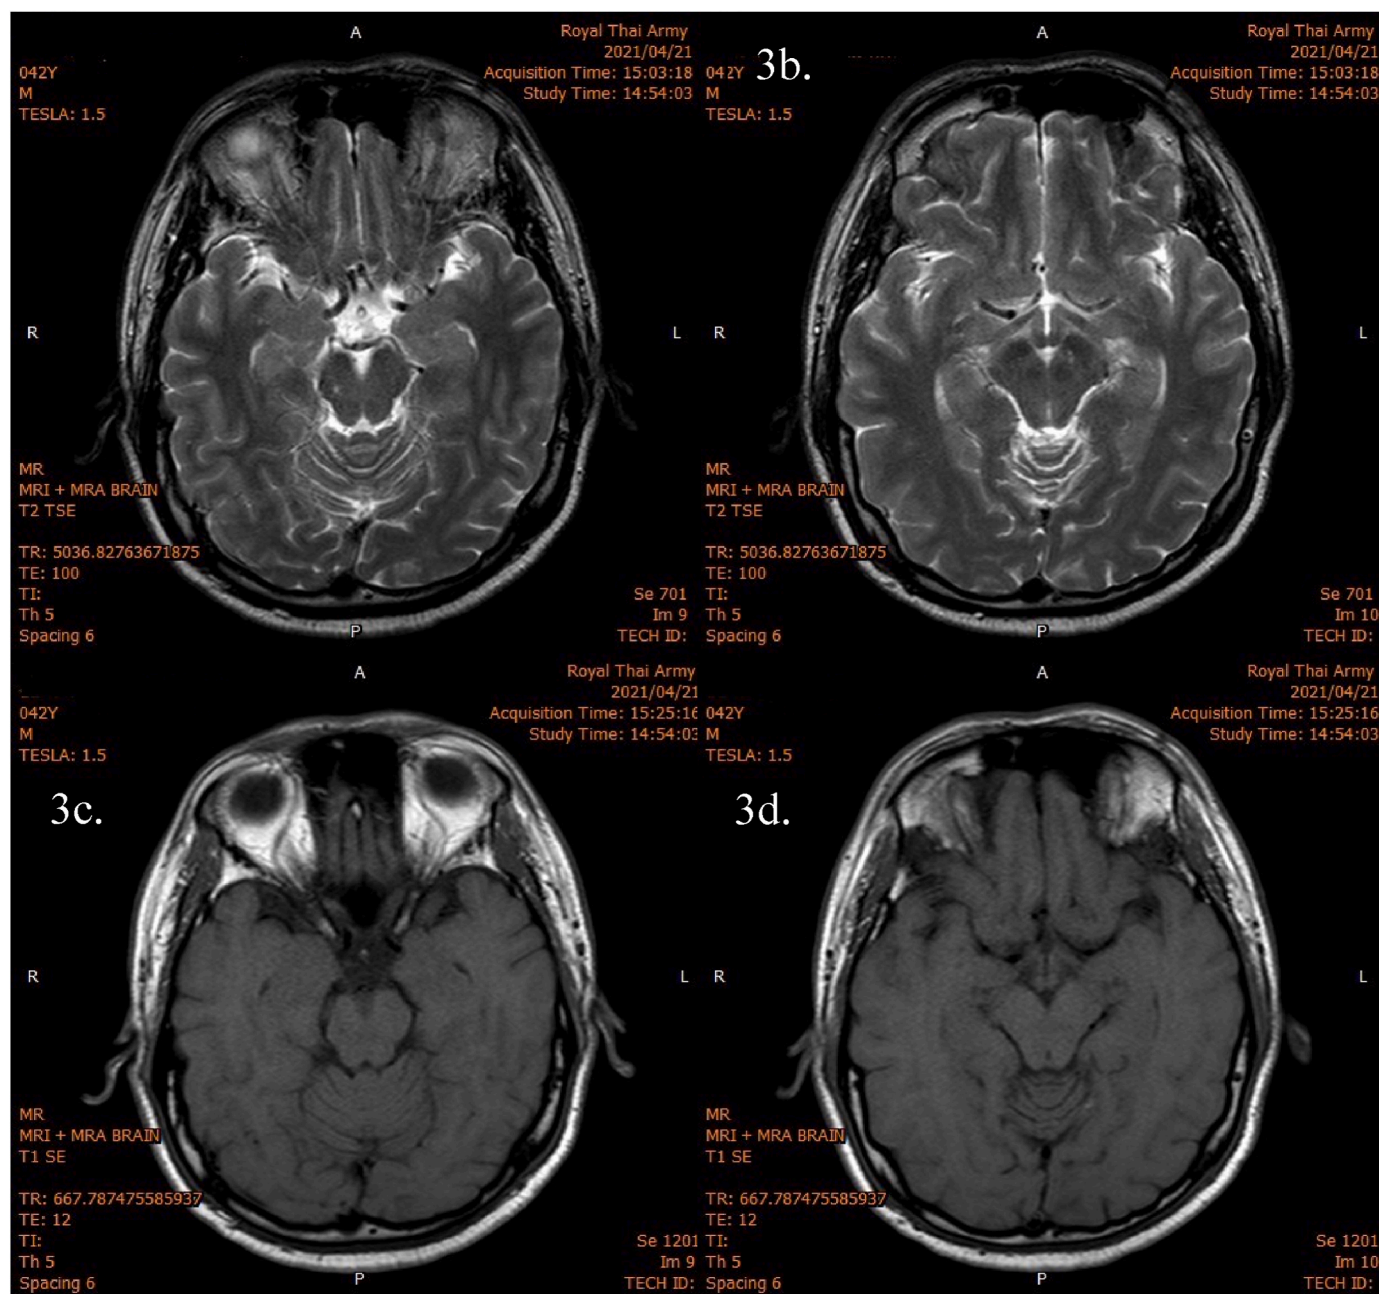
MRI brain imaging (diffusion-weighted imaging, DWI) showed no evidence of acute intracranial infarction, hemorrhage, significant stenosis, arteriovenous malformation (AVM) or aneurysm. There is a suspicion of an old lacunar infarction at right cerebral peduncle.
